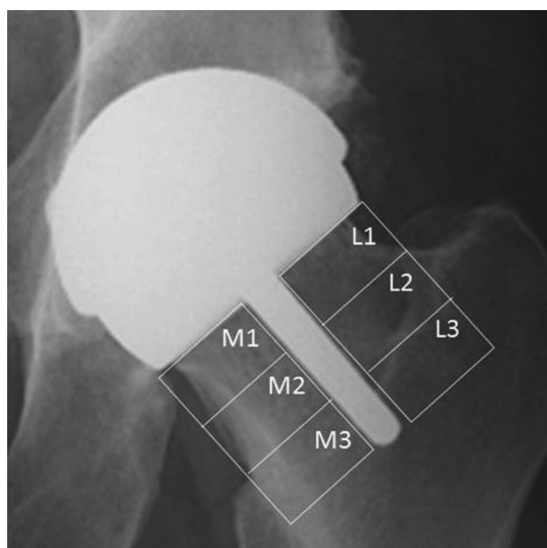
Radiograph demonstrating the 6 regions of interest in the femoral neck; L1–L3 correspond to lateral, and M1–M3 correspond to medial to the femoral stem.
